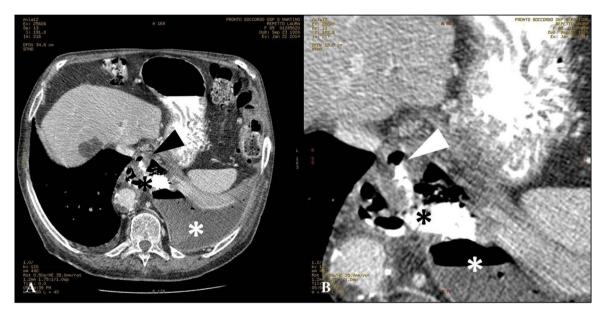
(a) CT scan shows the contrast leakage from the oesophagus (black arrowhead) into the large mediastinal collection (black asterisk). The loculated pleural effusion is also evident (white asterisk). (b) Enlarged vision. Oesophageal perforation (white arrowhead), mediastinal collection (black asterisk), pleural collection with an air-water level (white asterisk).
